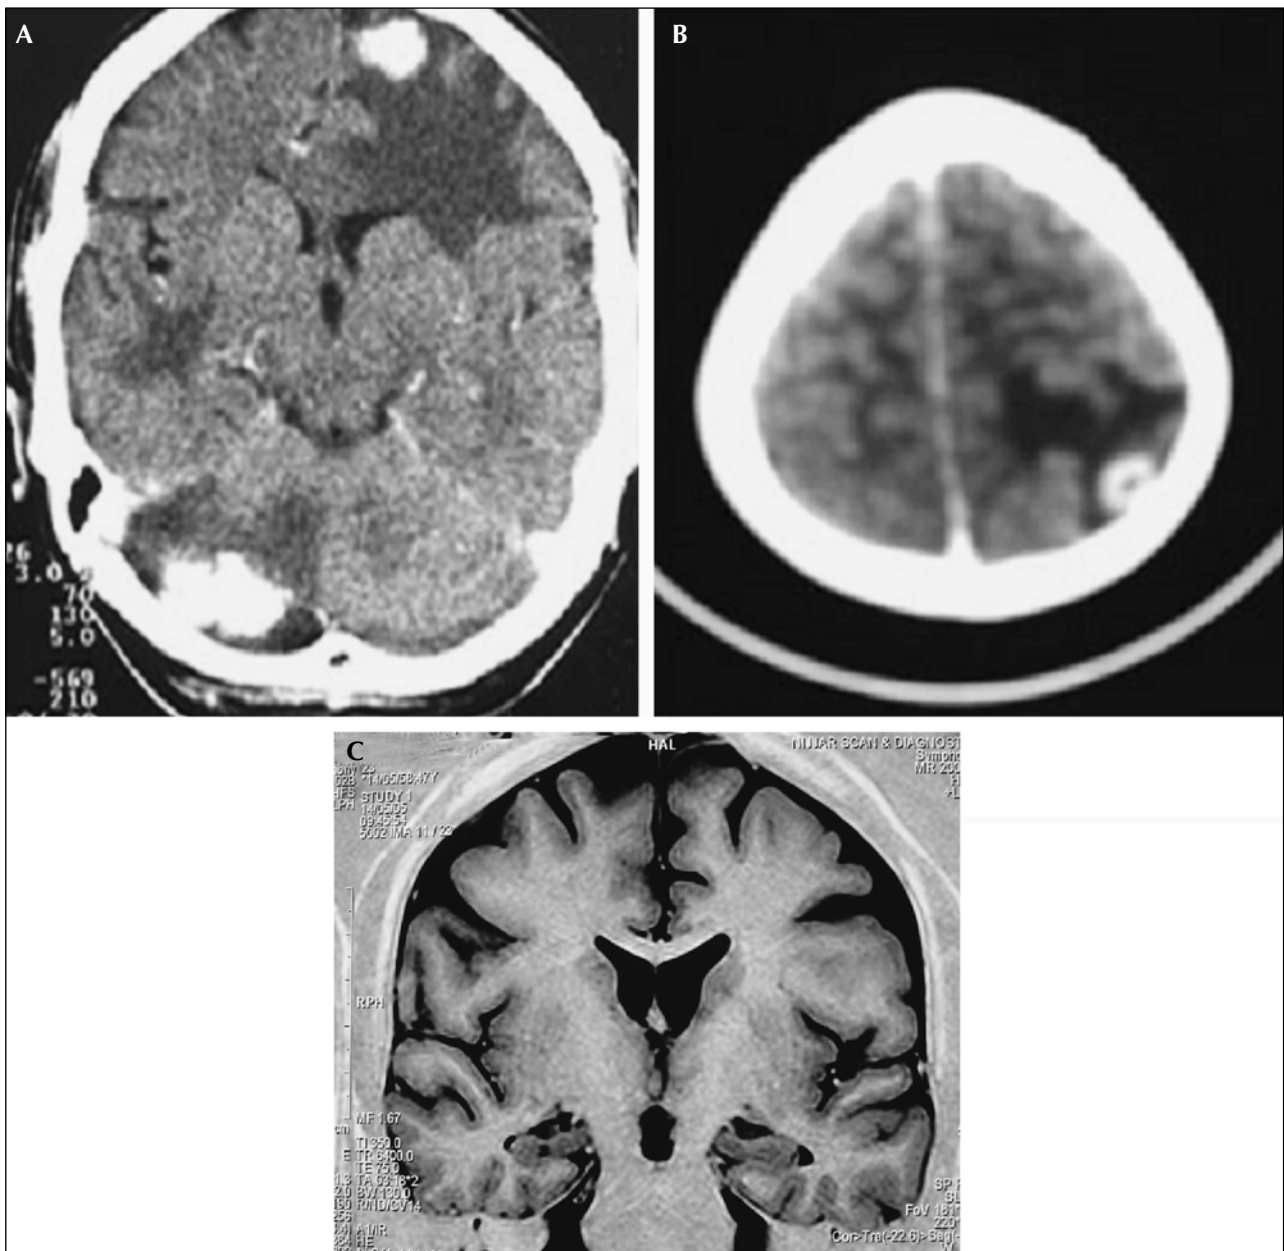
Case 2. A, B) Initial contrast enhanced CT sections showing multiple enhancing parenchymal lesions with surrounding edema. C) Follow-up MRI, T1 coronal oblique sections showing the smaller size of the hippocampus on the right side.
